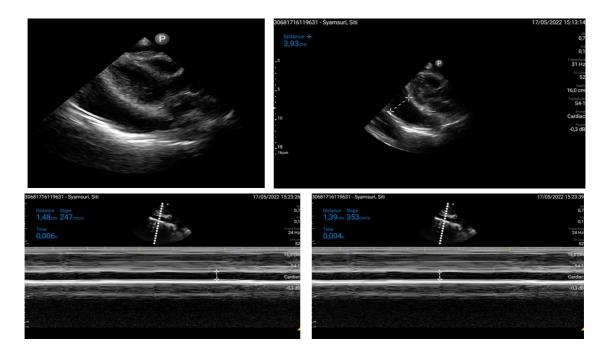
Pre-pericardiocentesis echocardiography in the patients.
